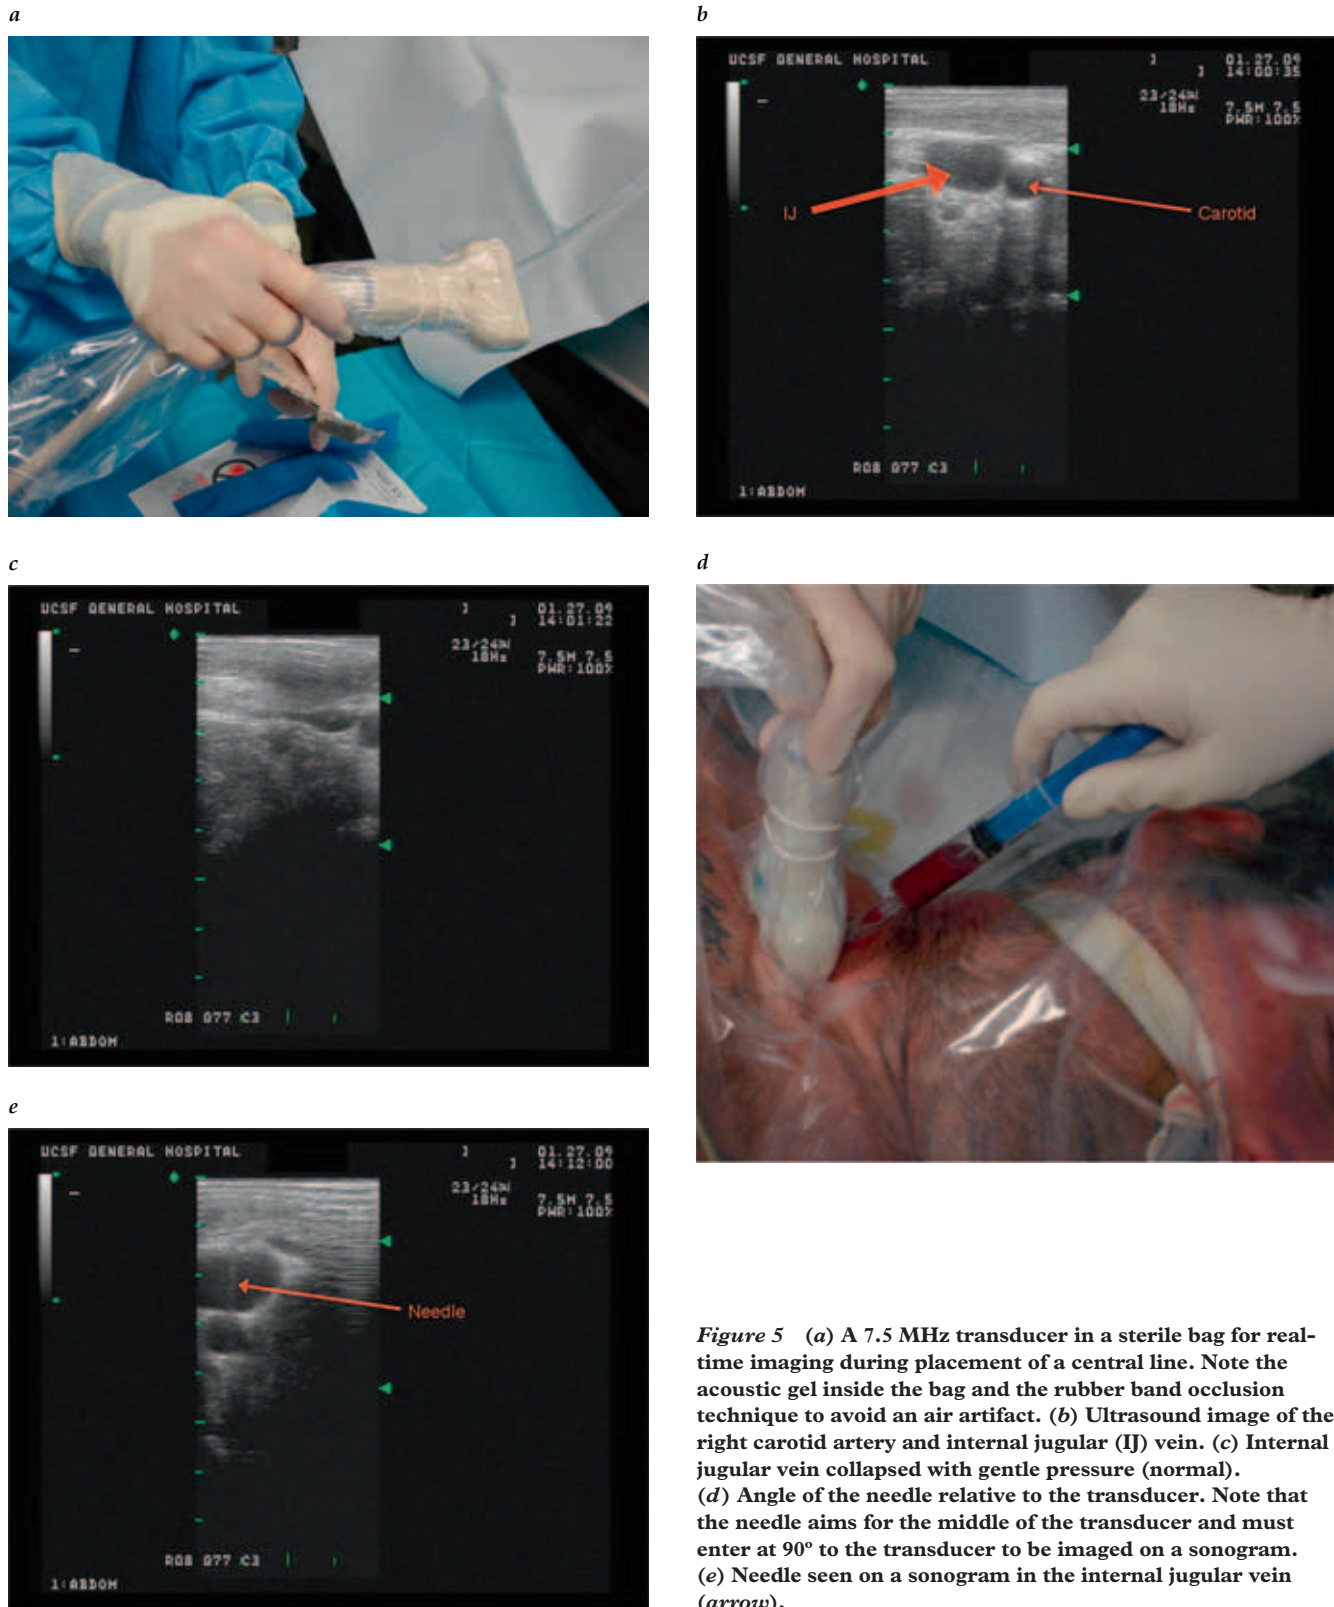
(a) A 7.5 MHz transducer in a sterile bag for real-time imaging during placement of a central line. Note the acoustic gel inside the bag and the rubber band occlusion technique to avoid an air artifact. (b) Ultrasound image of the right carotid artery and internal jugular (IJ) vein. (c) Internal jugular vein collapsed with gentle pressure (normal). (d) Angle of the needle relative to the transducer. Note that the needle aims for the middle of the transducer and must enter at 90° to the transducer to be imaged on a sonogram. (e) Needle seen on a sonogram in the internal jugular vein (arrow).
